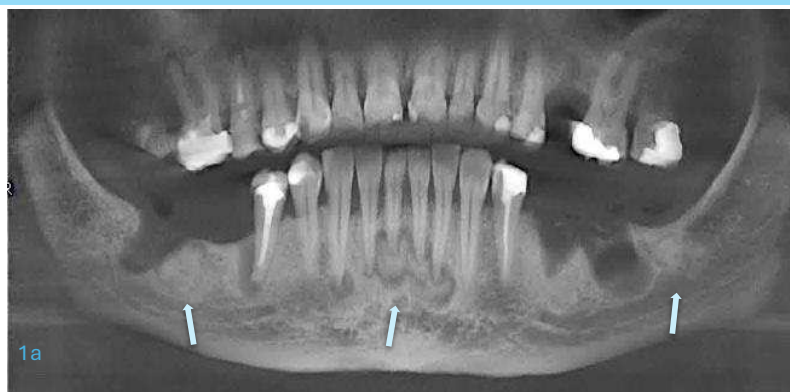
A panoramic view of a CBCT radiograph, showing radiopaque-radiolucent lesions in the periapical region of teeth 32, 31, 41, 42 and 43 with a well circumscribed radiolucent border. Note radiopaque lesions with a radiolucent border near the area of the extracted teeth 36 and 47.
